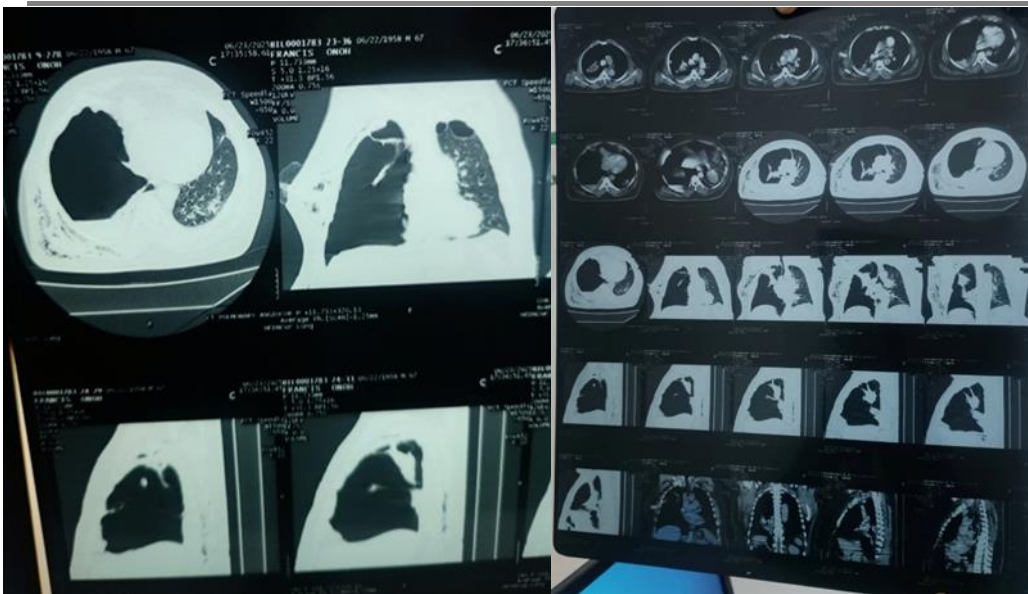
Chest CT-scan showing right pneumothorax with 1st chest tube in-situ but blocked before 2nd tube was inserted.
